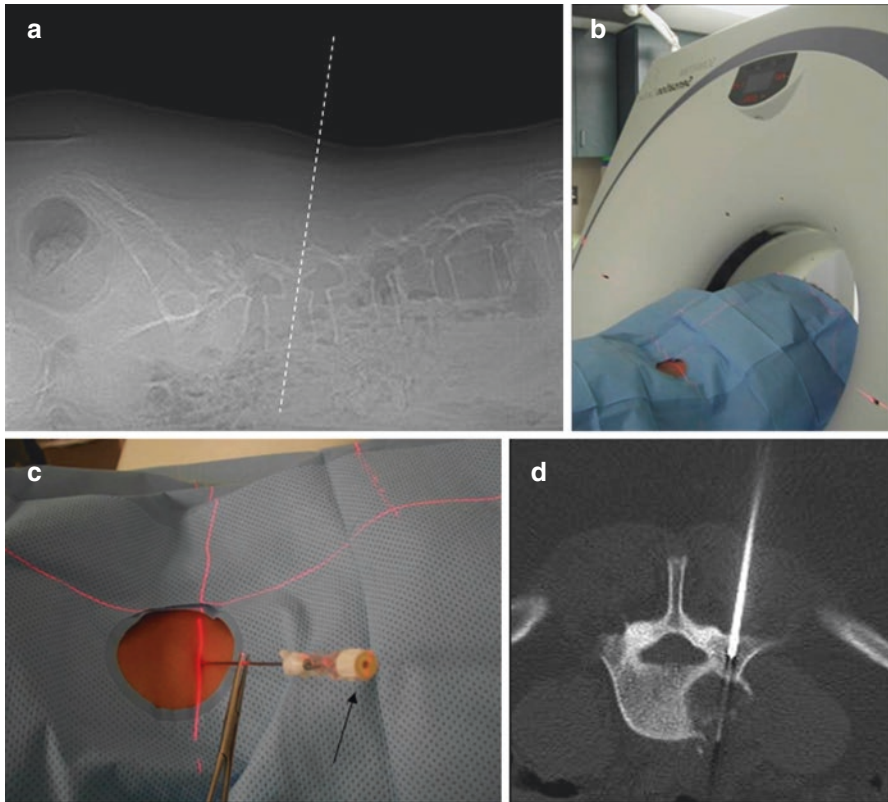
Gantry-needle-target alignment with CT guidance: on the lateral scout view (a), the desired access obliquity is defined, and the CT gantry is accordingly tilted (b), to acquire the localizing axial scan. Once the axial access slice is selected and the skin marked and prepped, the needle is aligned with the gantry using the gantry laser light. The laser light projects along the whole needle shaft (c), from the skin entry point to the needle hub (*black arrow* on c). The control CT scan shows the needle on one single slice, from the skin to the target (d)
